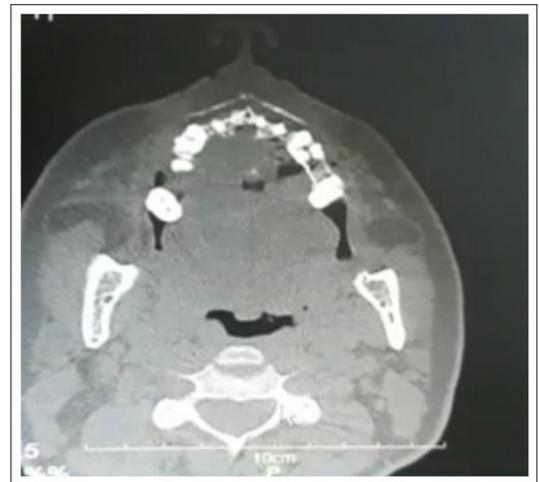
CT Scan Axial View
